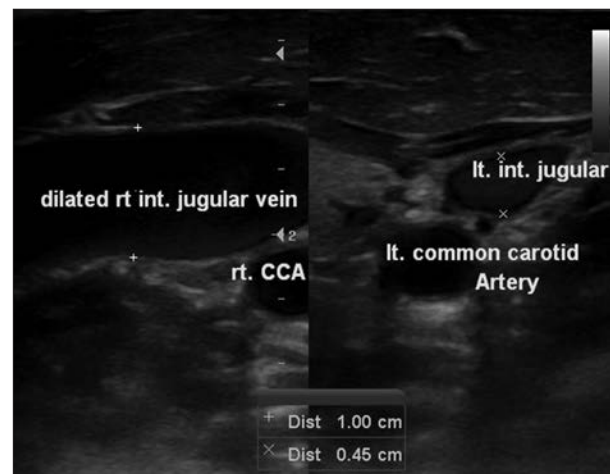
Doppler ultrasound of the neck of the same patient showing marked dilatation of the right internal jugular vein (original image)
